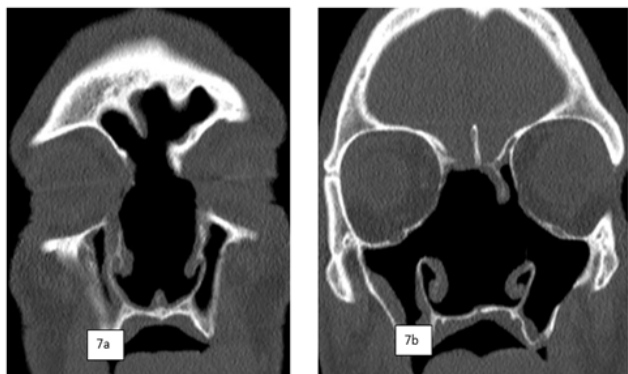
Bone window Sinus CT scan/coronal cuts/visualization of wide opened paranasal cavities without sinusitis or tumor recurrence.
